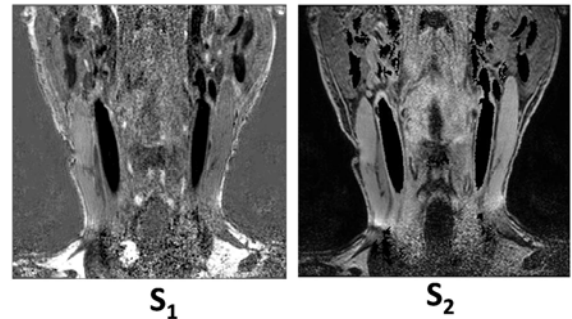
T1-weighted $S_1(x, y)$ and $S_2(x, y)$ corresponding to $I_1(x, y)$ and $I_2(x, y)$ in fig 1 are reconstructed using the polarity map $P(x, y)$. Note the vessel boundaries (lumen and outerwall) are clearly observed on $S_2(x, y)$
